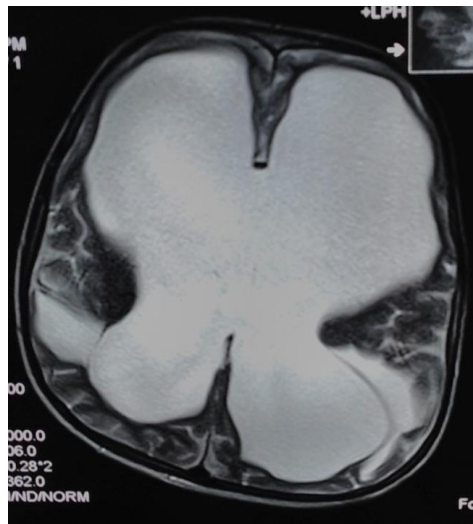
Axial T2 MRI image in a 10 years old male show massive hydrocephalus with periventricular edema.
